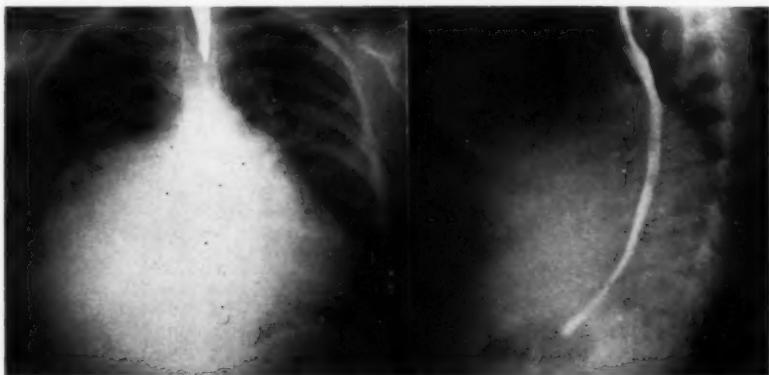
Posteroanterior and lateral chest roentgenograms of E. D., patient 8, Table 1. Note giant left atrium.
